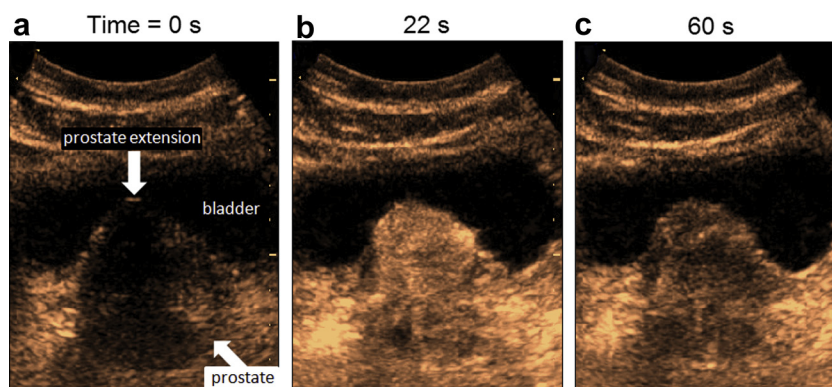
Three selected frames from the transabdominal dynamic contrast-enhanced ultrasound scan (a) before ultrasound contrast agent wash-in, (b) at peak concentration and (c) during washout, revealing a hypervascularized prostate extension toward the bladder. The bladder, prostate and a prostate extension into the bladder are indicated in (a).
